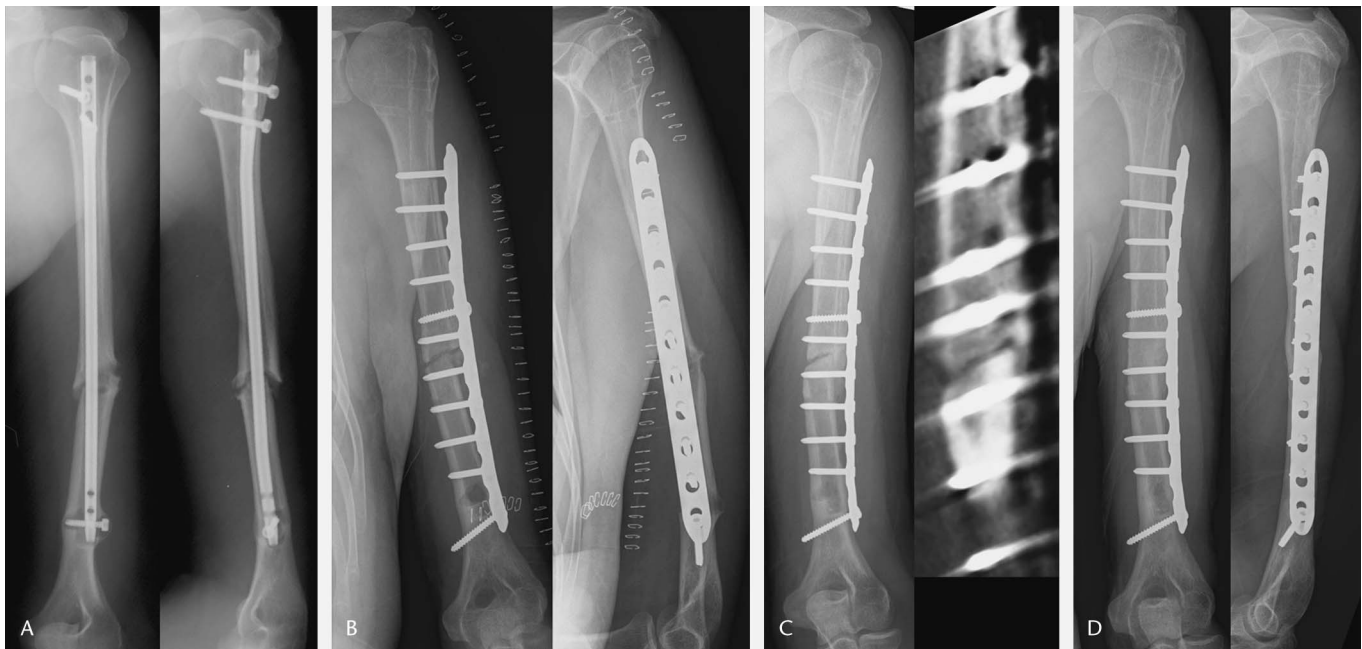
A, Anteroposterior and lateral radiograph of a 37-year-old man (patient 31), who was referred 24 months following intramedullary nail fixation of a humeral shaft fracture. The patient had no significant past medical history and the workup for infection, including aspiration of the nonunion site and blood work, was negative. The patient was taken to the operating room and underwent nail removal, trimming of the nonunion site, autogenous posterior iliac crest bone grafting, and plate stabilization with compression applied across the nonunion site. B, Anteroposterior and lateral radiographs 2 weeks following nonunion treatment as described above. C, Anteroposterior radiograph and CT scan 6 months later shows a persistent nonunion with no cross-sectional area of healing. At this point the patient continued to complain of pain and was referred for endocrinology evaluation. The evaluation revealed vitamin D deficiency [the patient had high intact parathyroid hormone (83 pg/mL) and low 25-hydroxyvitamin D (14 ng/mL)]. The patient was started on calcium 500 mg with vitamin D 800 IU three times per day to treat his vitamin D deficiency. D, Anteroposterior and lateral radiographs 5 months following initiation of medical treatment show solid bony union; no further operative intervention was performed. The patient has returned to full painless function at preinjury levels.
